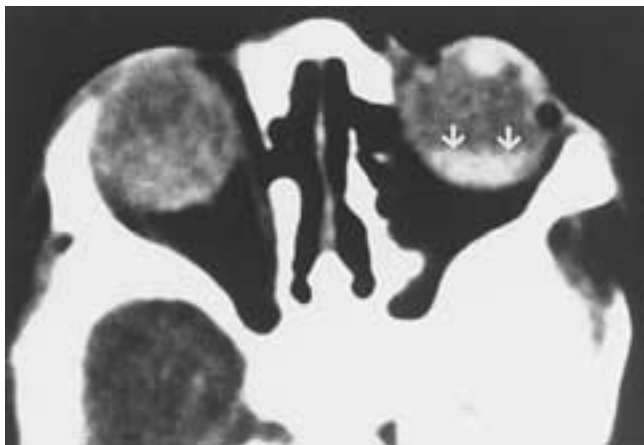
PHPV. Axial CT scan shows an increase in the density of both vitreous chambers, with gravitational layering of high-density fluid in the left eye (arrows). The high-density fluid is most likely caused by blood in the subhyaloid space.
